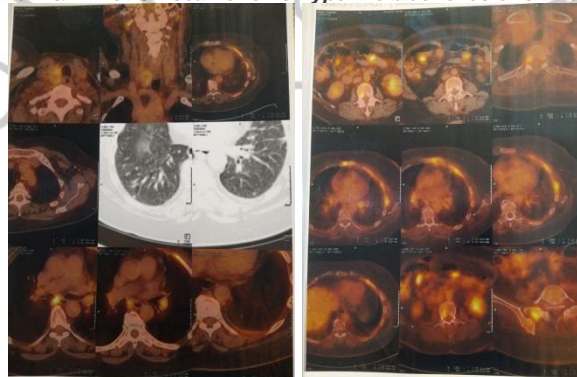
Multiple bone metastases in bone in PET CT scan.
